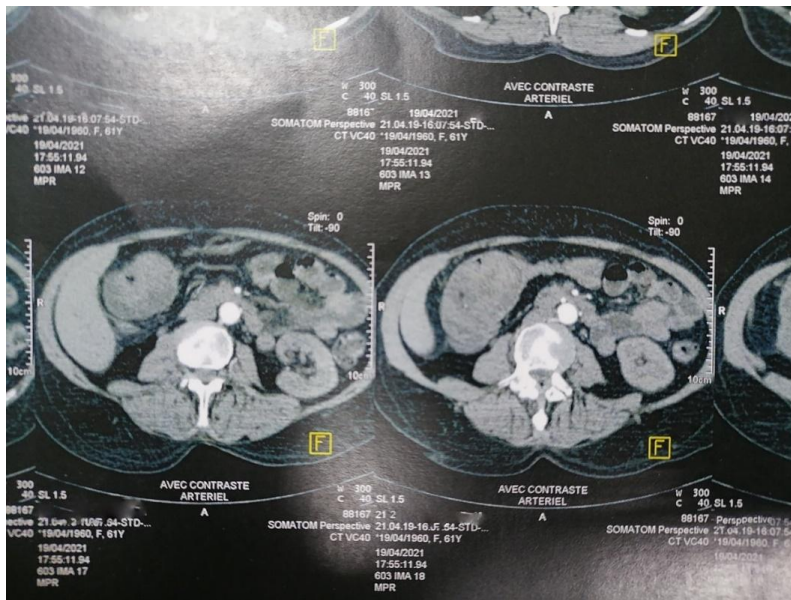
Abdominal CT scan showing an aspect of ileocolic intestinal invagination
